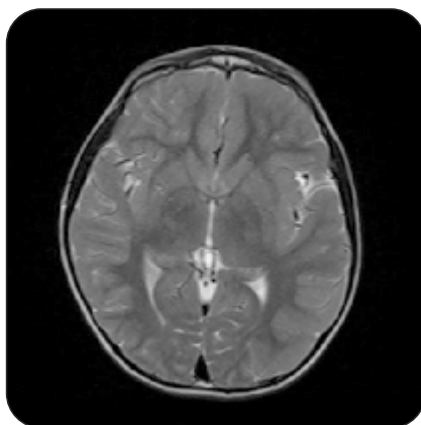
Magnetic Resonance Imaging (MRI) scan
